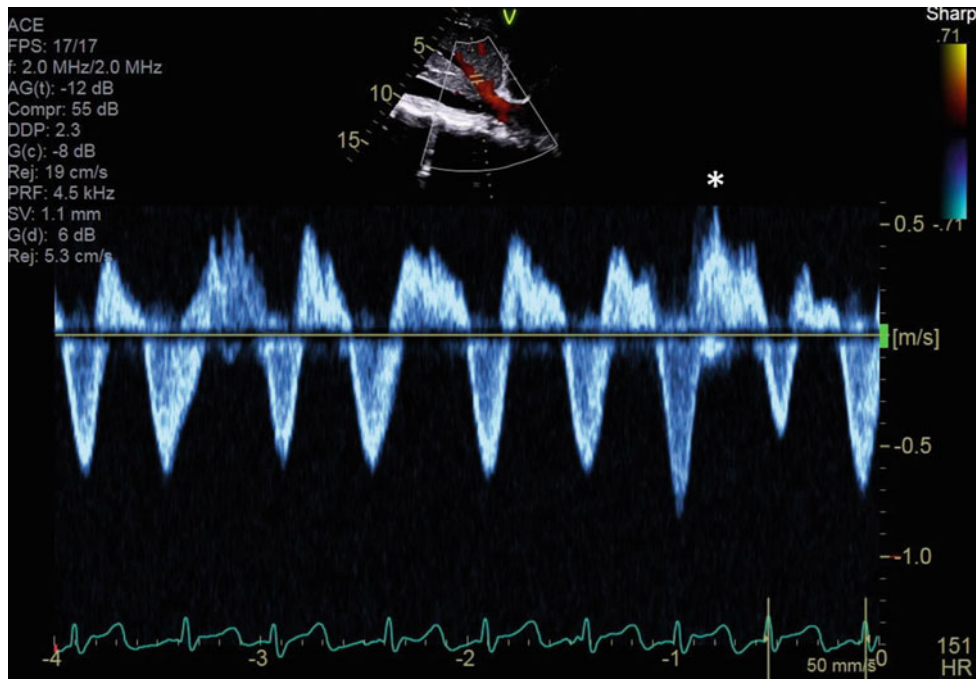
Although there is no respirator during the pulse doppler of the hepatic veins, there is variation and reversal of the flow during late diastole (see *)
